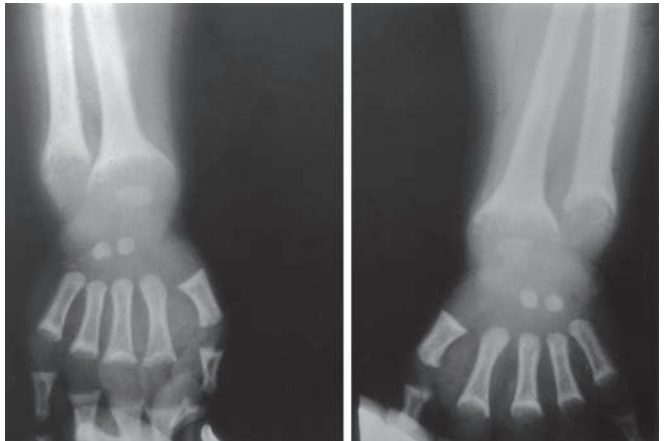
X-rays of wrists and hands showing changes caused by rickets
